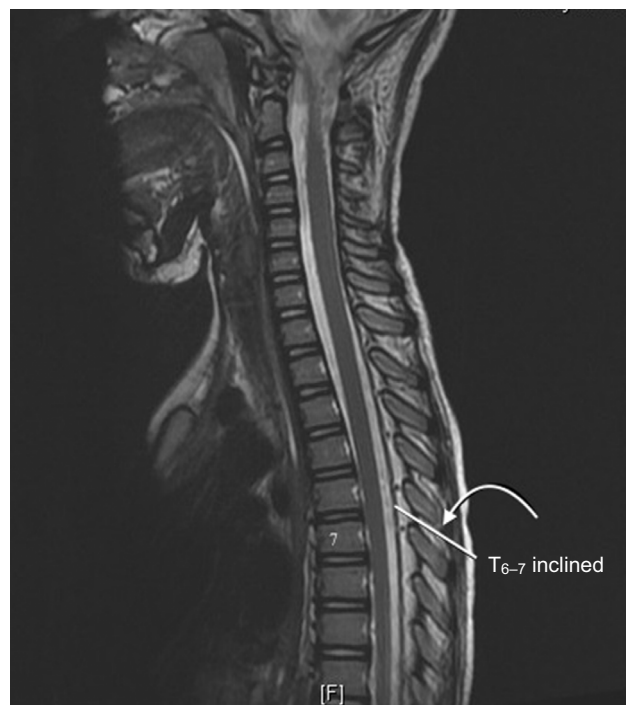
Magnetic resonance image of the thoracic spine and vertebral bodies showing technique for the measurement of the inclined skin to epidural depth at the T_{6-7} interspace.
